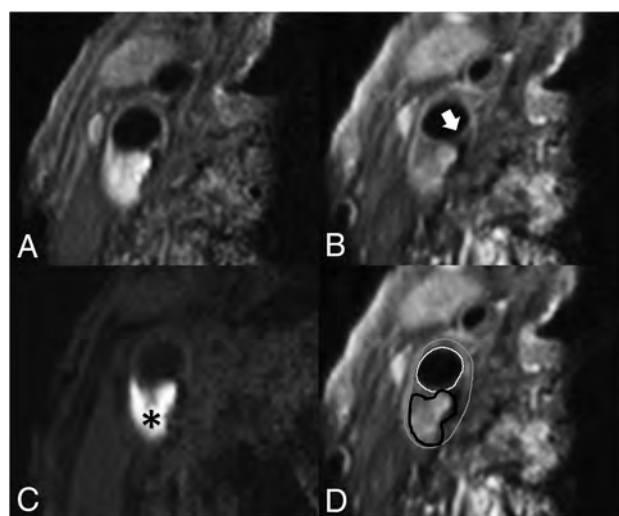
Transversal MR images of carotid plaque in the right carotid artery. We acquired the following MR images: precontrast T1-weighted QIR TSE (A), postcontrast T1-weighted QIR TSE (B), T1-weighted inversion recovery turbo field echo (C). D, The same image as in B, including the contours delineating intraplaque hemorrhage and the inner and outer vessel wall: white = lumen, gray = outer vessel wall, black = intraplaque hemorrhage. C, A hyperintense signal in the bulk of the plaque can be clearly observed, indicating the presence of intraplaque hemorrhage (black asterisk). B, An interruption of the signal enhancement adjoining the lumen can be observed, indicating a TRFC (white arrow).
